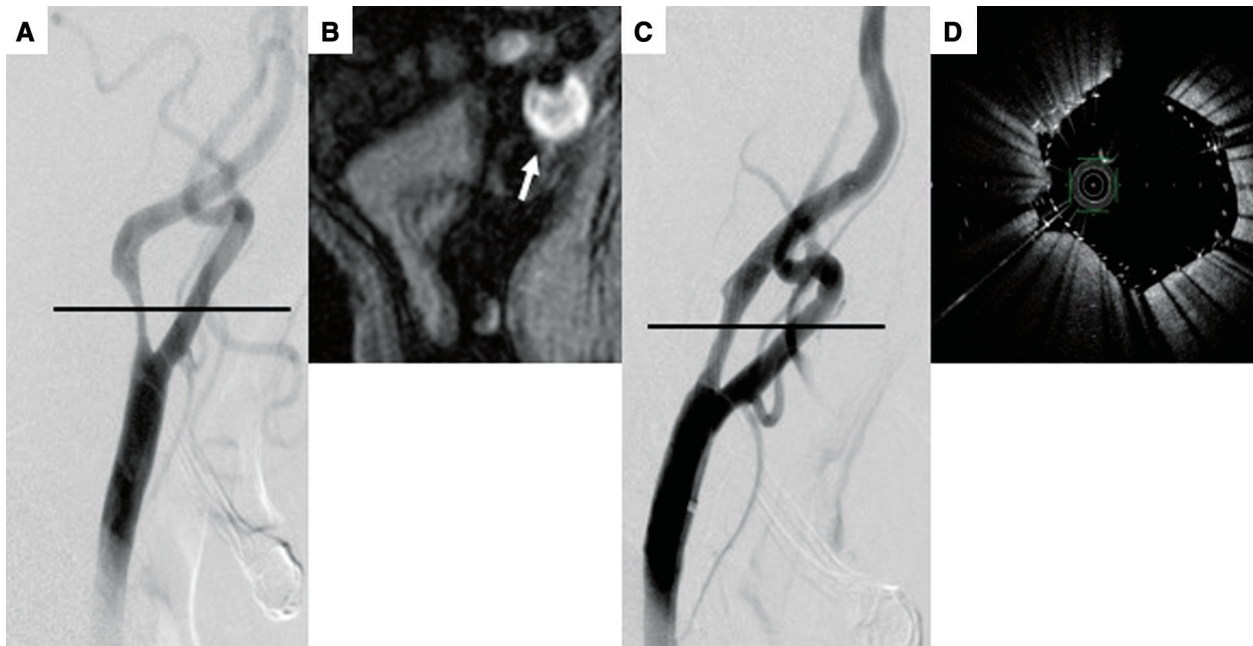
Representative images that were negative for PP. A case of symptomatic left carotid artery stenosis and unstable plaques treated with a CASPER stent. (Moderated and cited from Yamada et al.²²) with permission from Elsevier. (A) DSA before CAS. (B) T1-weighted MRI of the carotid plaque demonstrating unstable plaques (signal intensity ratio with adjacent muscle was 2.62: white arrow). (C) DSA after CAS. The stenotic lesion was successfully dilated. (D) OFDI after CAS showing absence of PP. CAS: carotid artery stenting; DSA: digital-subtraction angiography; OFDI: optical frequency domain imaging; PP: plaque protrusion
